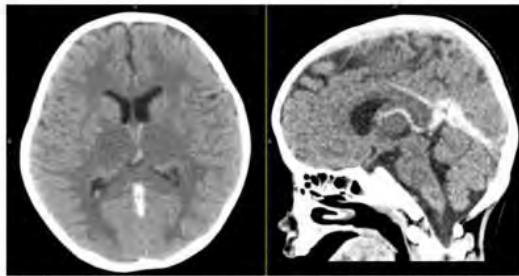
Non-contrast Cranial CT
